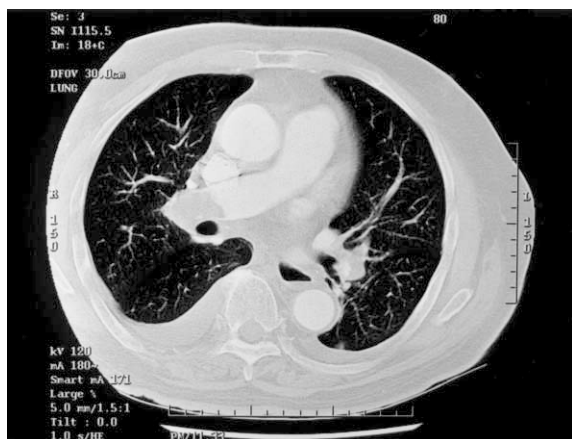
Spiral CT Scan showing filling defect in the proximal right main pulmonary artery. Thrombus also seen in the left basal pulmonary artery. Incidentally bilateral pleural effusion is also noted.
